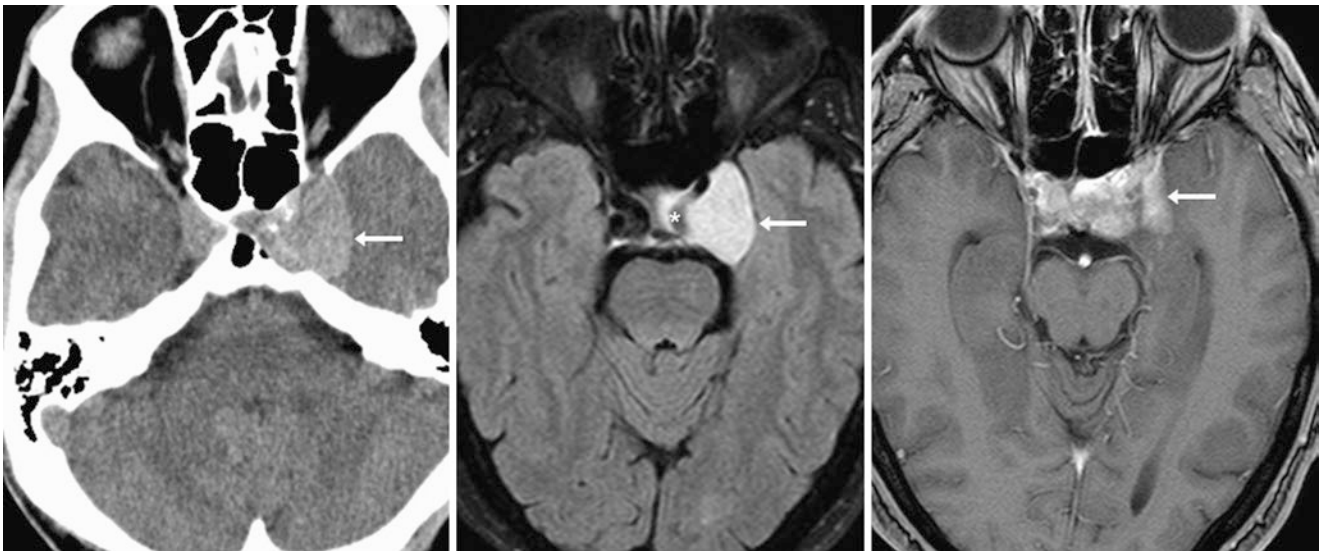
Comparison case of meningioma. A 52-year-old male had a mass within the left cavernous sinus (*arrows*) that was isodense to the ICA and overall mildly hyperdense on axial NECT (*left*), on 1.5 T FLAIR MRI (*middle*), and on postcontrast T1WI (*right*). Note the left ICA (*) surrounded by the mass on FLAIR
